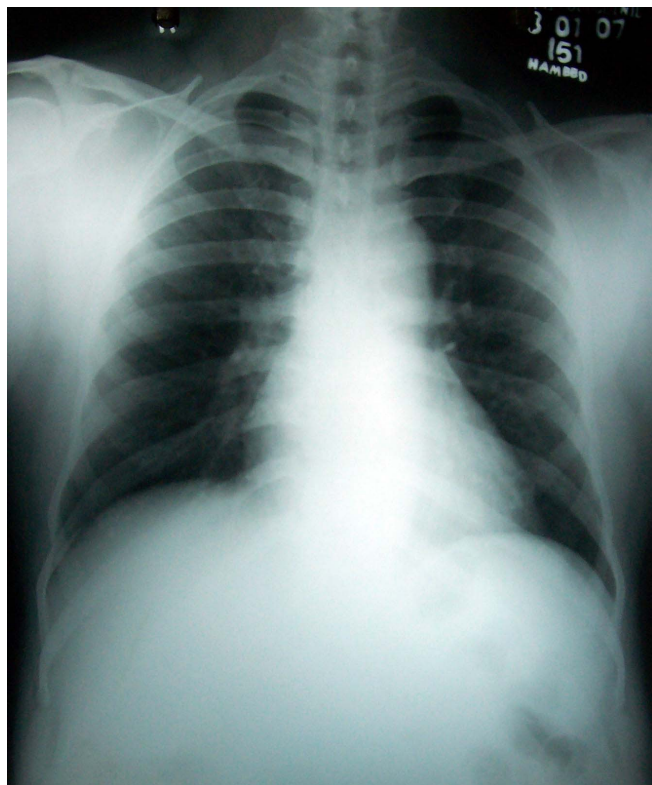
Showing normal Chest X-ray
